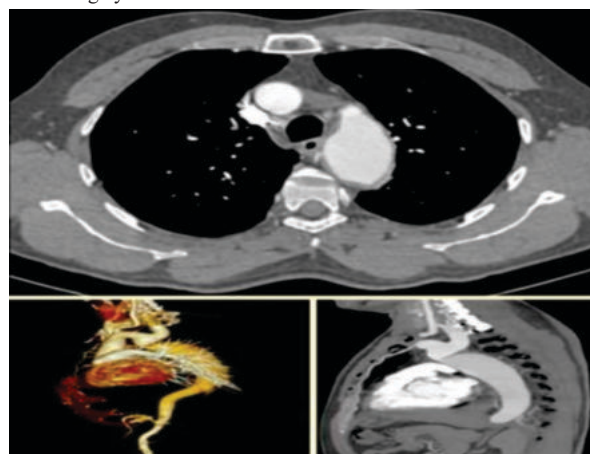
CT aortogram showing significant coarctation of the thoracic aorta beyond the origin of the left subclavian artery (arrow) with post stenotic dilatation.
